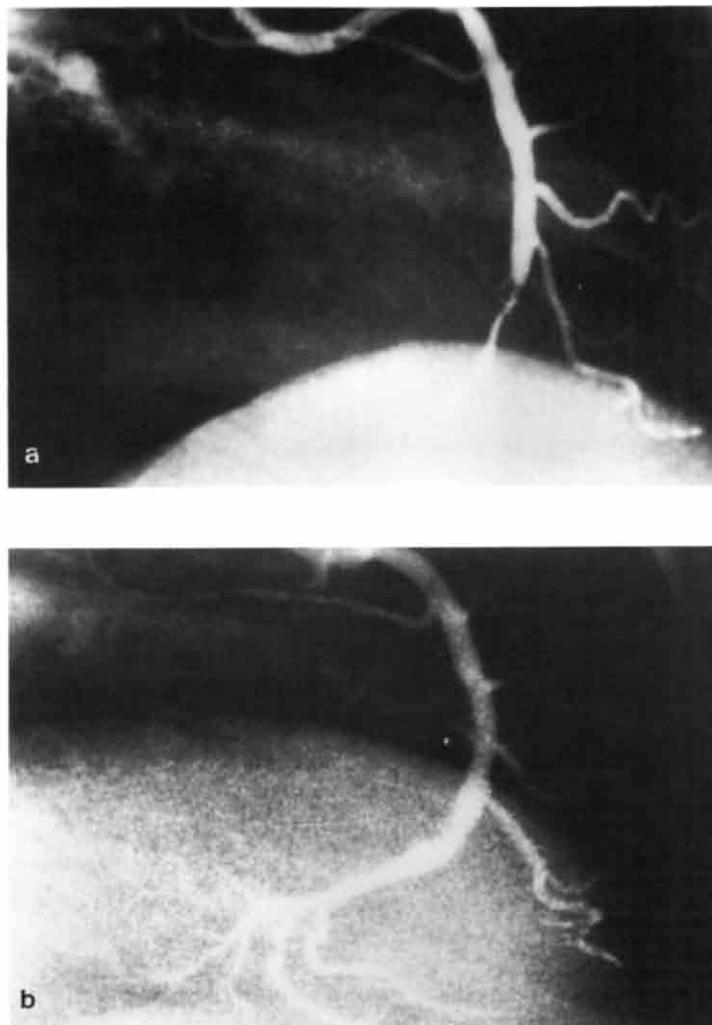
X-ray fluoroscopy images of (a) a blocked artery and (b) the artery after laser angioplasty. (Courtesy of Advanced Interventional Systems.)
